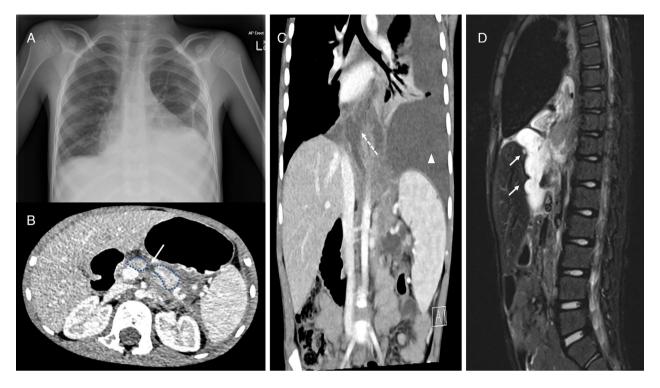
Chest X-ray (CXR) on presentation (A), discontinuity between the pancreatic body (blue outline) and a pancreatic collection (long arrow) (B), mediastinal collection (dotted arrow) and pleural effusion (arrowhead) (C), and posterior mediastinal collection (short arrows) (D).
